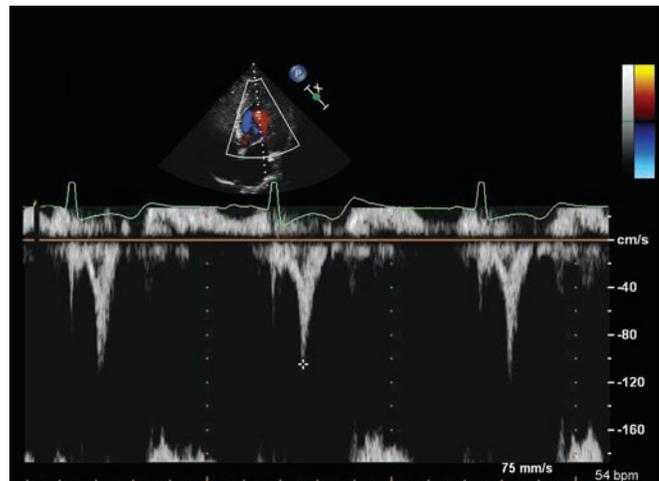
LV intracavity PW Doppler assessment. Pressure gradients are not significantly raised (PG 4 mm Hg).
